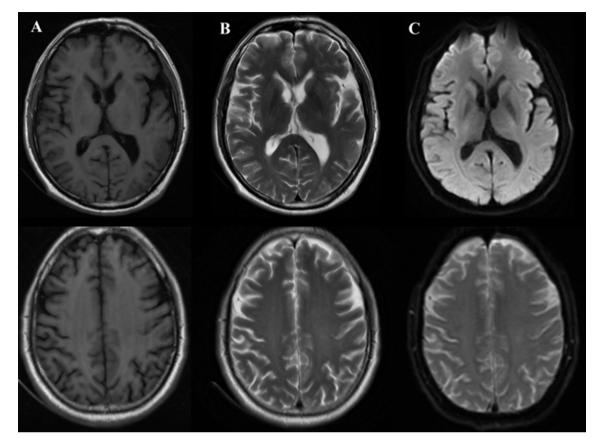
Cranial MRI-3.0T (A. T1WI B. T2WI C. DWI)
